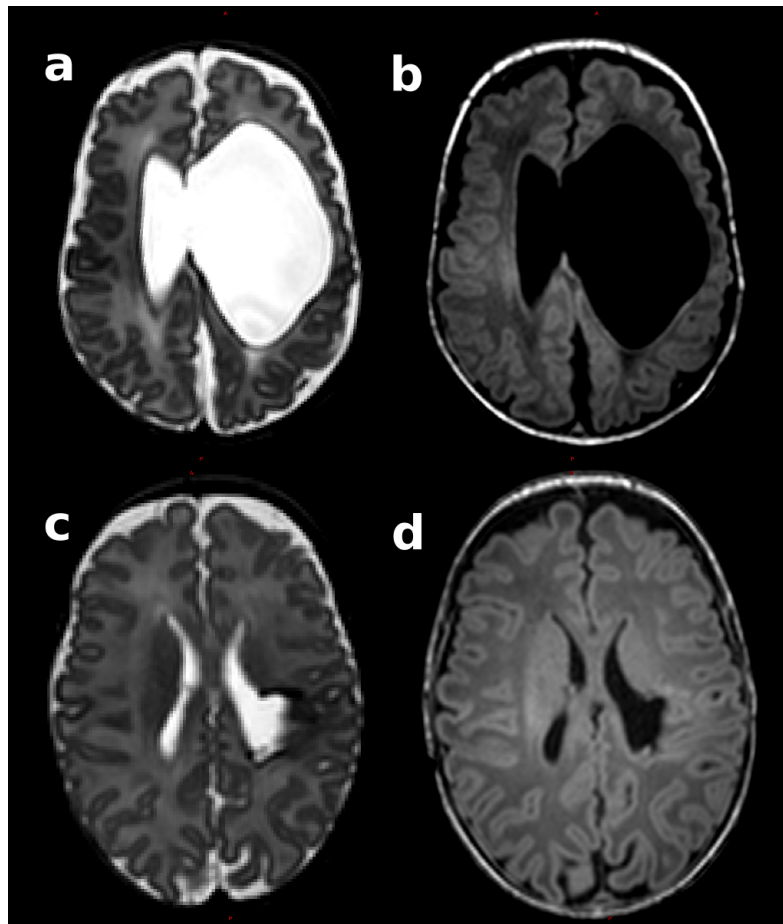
Haemorrhagic parenchymal infarct (HPI) in two preterm infants. The top row shows axial T2- (a) and T1-weighted (b) images of an HPI in an infant born at 25.7 weeks GA and imaged at 41.6 weeks PMA. The bottom row shows axial T2- (c) and T1-weighted (d) images of an HPI in an infant born at 30.0 weeks GA and imaged at 42.4 weeks PMA.
